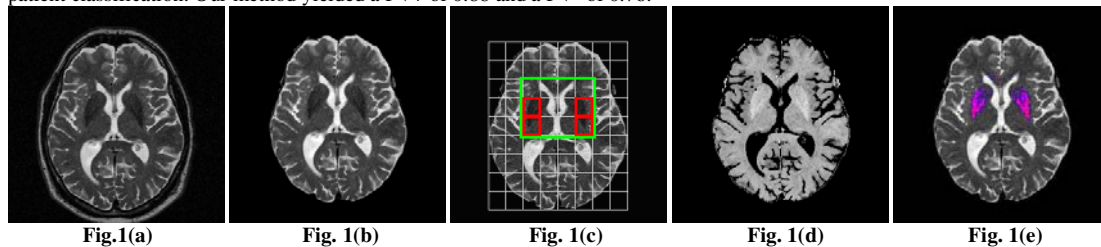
The original T2-w MRI in 1(a), its skull stripped and vertically aligned brain image in 1(b), the 8 by 9 rectangular grid superimposed on image 1(b) in 1(c); the green rectangle in 1(c) is the ROI and the four red blocks include large areas of the Lenticular Nucleus. The image of the $HypoMR$ feature, normalized and scaled from 1 to 255 is shown in 1(d). Fig 1(e) shows the pixels (Lenticular Nucleus) with $HypoMR > 0.70$. Pixels in light purple are more hypointense than the pixels in blue.
